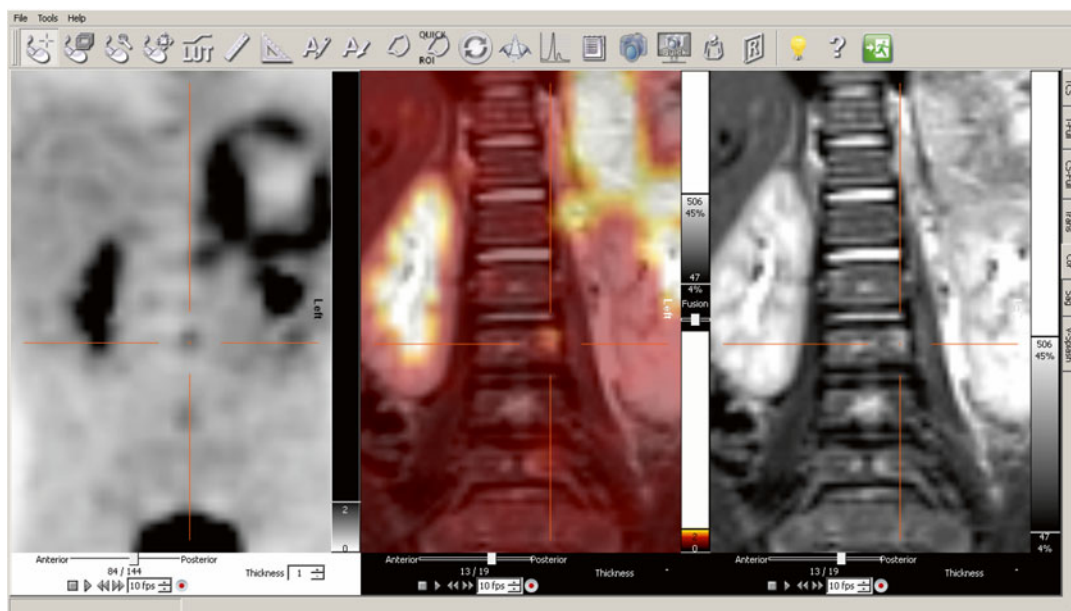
Multimodality display on a Hermes workstation (Nuclear Diagnostics AB, Haegersten, Sweden) demonstrating a large left-sided paravertebral neuroblastoma in ^{18}F -FDG PET (*left image*) and T2-weighted MRI (*right image*). By synchronizing images, even small bone
